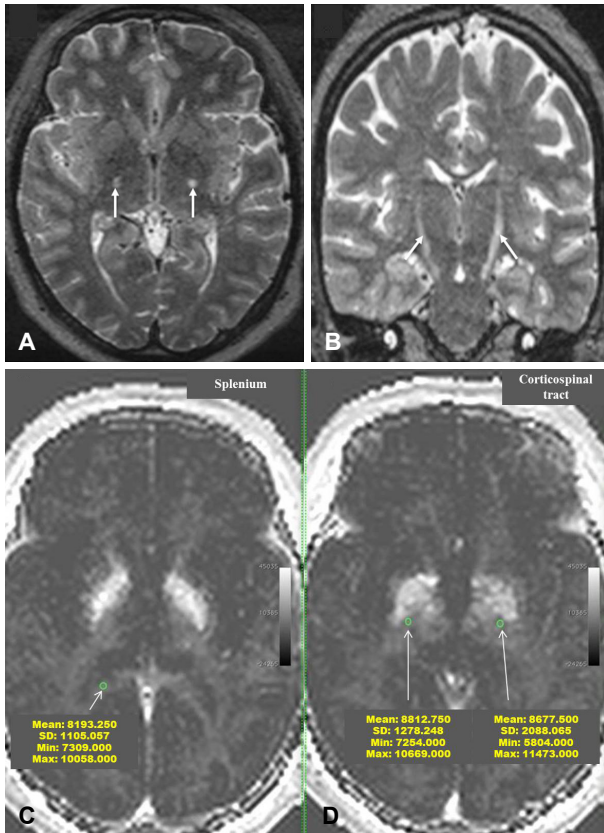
(A, B) Axial (A) and coronal (B) T2-weighted MRI of the brain display bilateral high signal intensity along the corticospinal tract (CST) (white arrows). (C, D) The mean myelin quantity was larger in the CST area than in the adjacent splenium of corpus callosum (right CST = 8,812, left CST = 8,677, splenium = 8,193) (green circles). MRI; magnetic resonance image.
